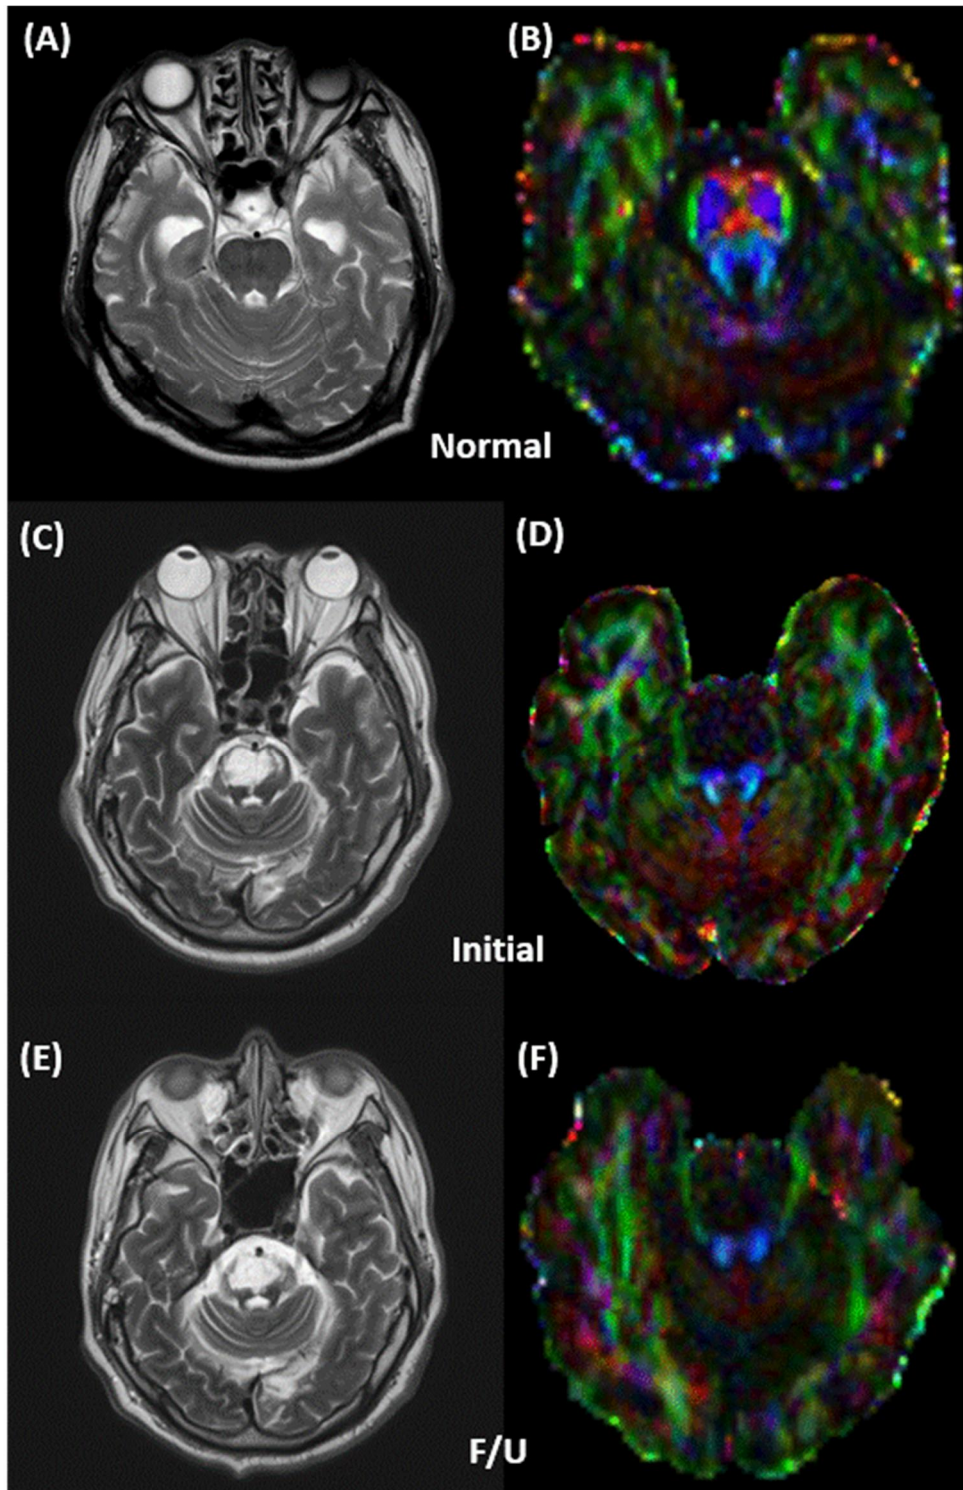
Brain MRI T2WI (left) and color FA map (right) of (A-B) healthy person, (C-D) our patient at 3 months after the onset, and (E-F) at 6 months after the onset. On T2WI, cystic encephalomalacic changes were observed in (C) and (E). On color FA maps, the location of CST represented by the blue fibers of the anterior pons in healthy person. (B) However, there were no clearly visible blue fibers in our patient. (D, F)
